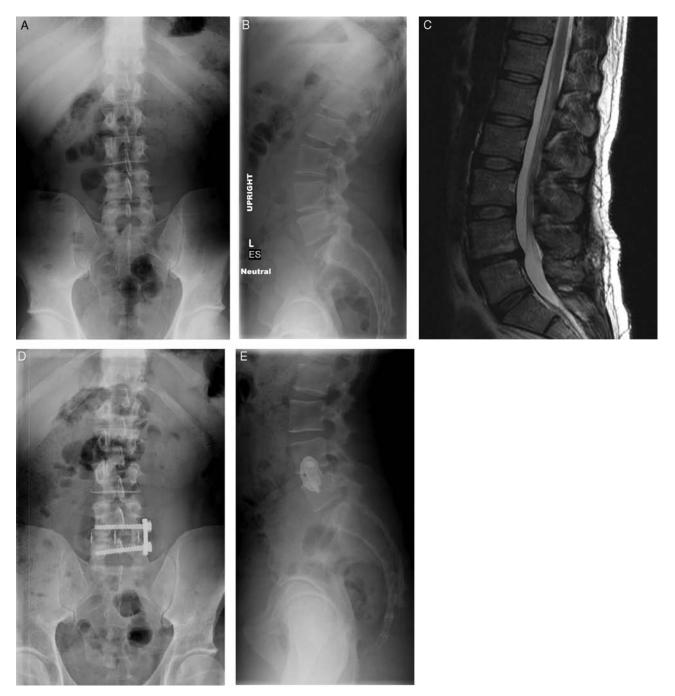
A 36-year-old man with chronic, axial low back pain secondary to L4-5 degenerative disc disease, unresponsive to nonoperative treatment. The patient had a positive discogram with concordant pain at L4-5 and a negative control at L5-S1. Pre-operative, anteroposterior (A) and lateral (B) radiographs, and sagittal T2-weighted MRI (C). The patient underwent an L4-5 XLIF with supplementary lateral plate fixation. Post-operative anteroposterior (D) and lateral (E) radiographs.
